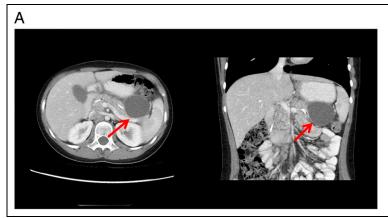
Scans of pancreatic pseudocyst (arrow). A. Computed tomography. B. Ultrasonography. Courtesy: William M. Peterson II, MD, and Sameh Tadros, MD, MSc, Department of Radiology; Children's Hospital of Pittsburgh of UPMC.
